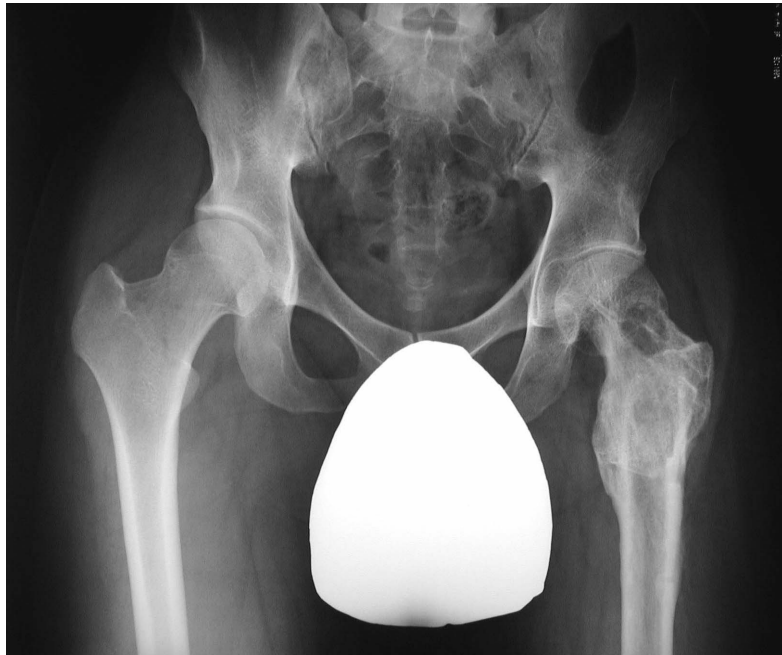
Plain radiography showing no recurrence or varus deformity at four years after surgery.
